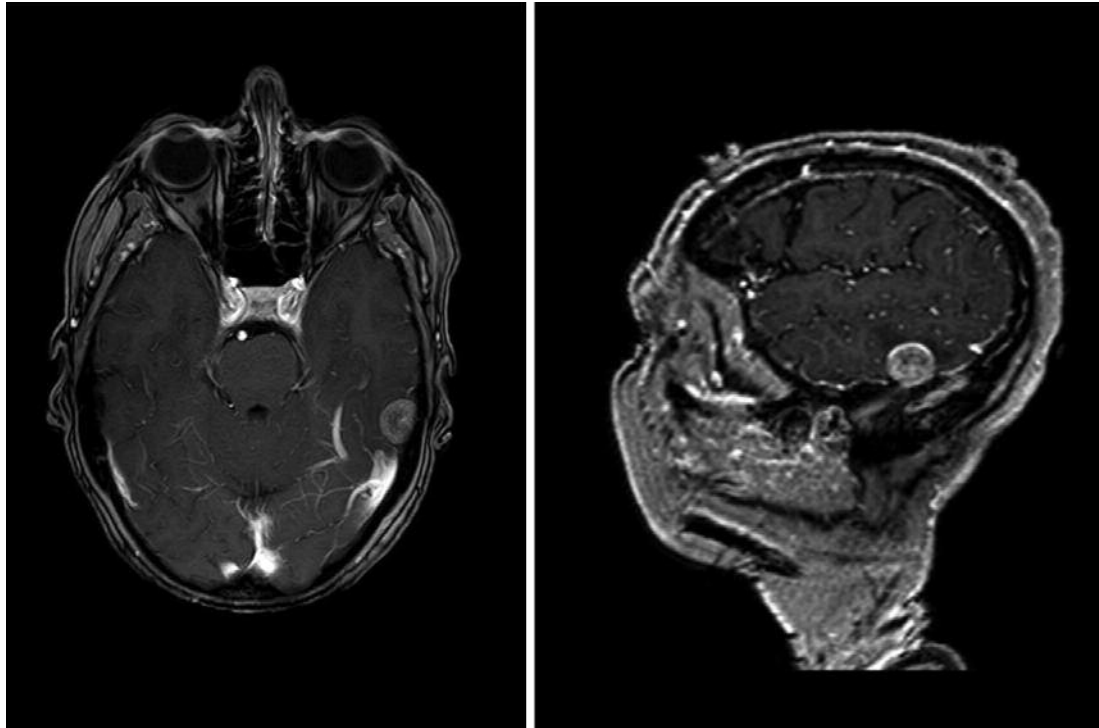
Cranial magnetic resonance imaging (MRI) revealed a left temporal mass with slight perifocal edema on transverse (left) and sagittal (right) section.
